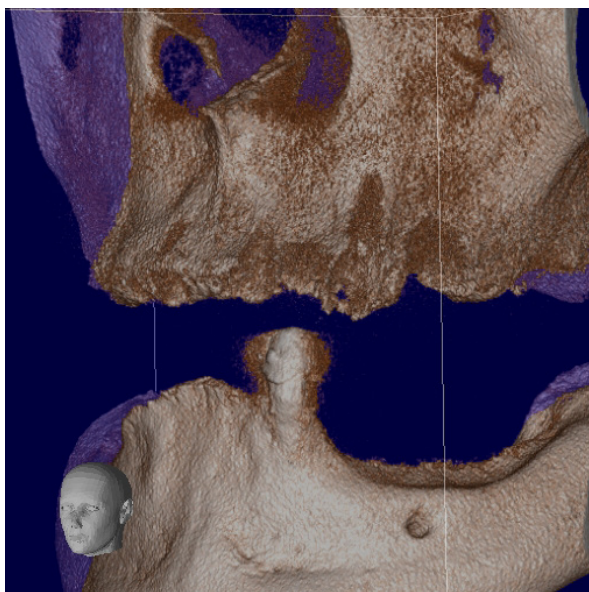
Bone defects and remaining tooth in CT scan image.
